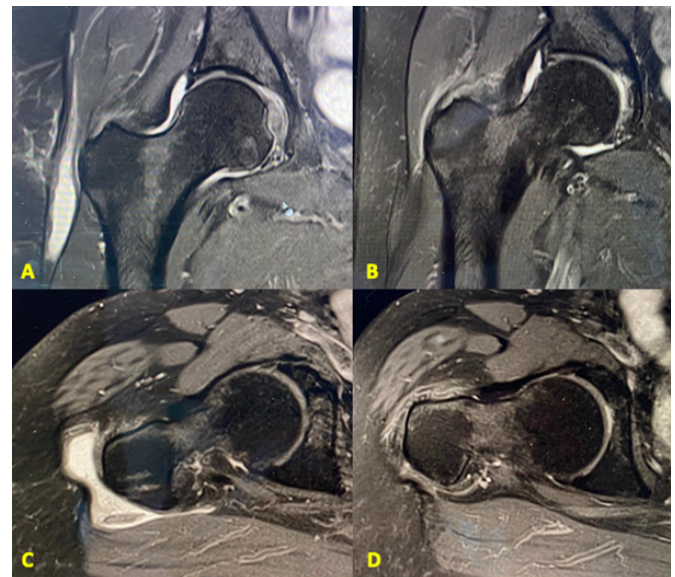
Preoperative MRI in coronal (A) and axial (C) slices with evidence of partial rupture of the GM tendon on its medial side. Follow-up MRI at three months in coronal (B) and axial (D) slices showing continuous scar tissue of the GM tendon.
